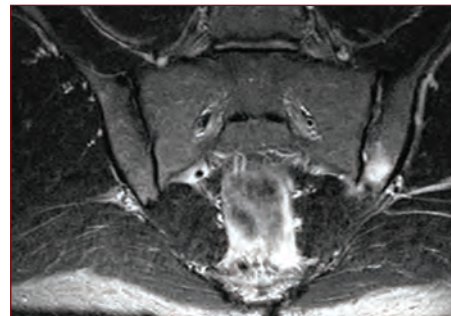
The STIR sequence of the first MRI scan shows bone marrow edema in the left lower iliac bone that is intense and should prompt strong suspicion.
